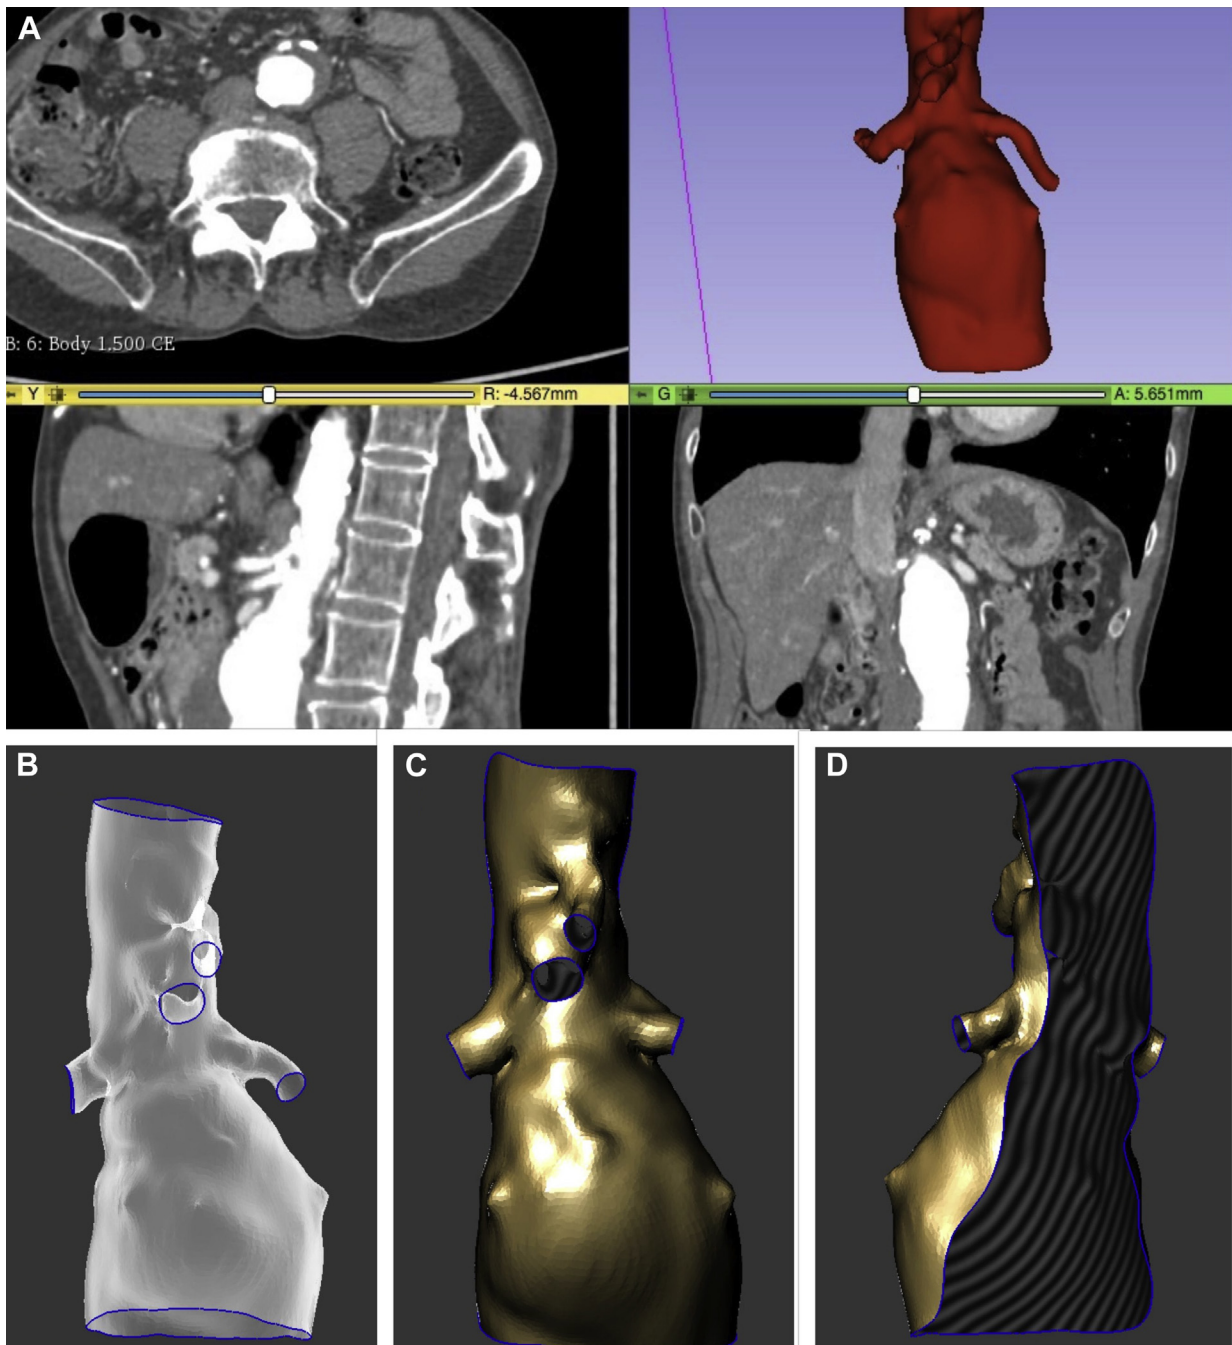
Aortic aneurysm three-dimensional (3D) model creation. Segmentation is performed with 3D Slicer software using the computed tomography (CT) Digital Imaging and Communications in Medicine files. Multiplanar views and the software tools are used to obtain an aortic 3D model that is saved as an STL file (A). This file is exported to a computer-aided design software (Meshmixer) by which the original model is converted into a hollow piece (B). The aortic surface is analyzed, and the vessels and posterior half of the aorta are cut to obtain a final template model that replicates the exact anatomy of the patient (C and D).
